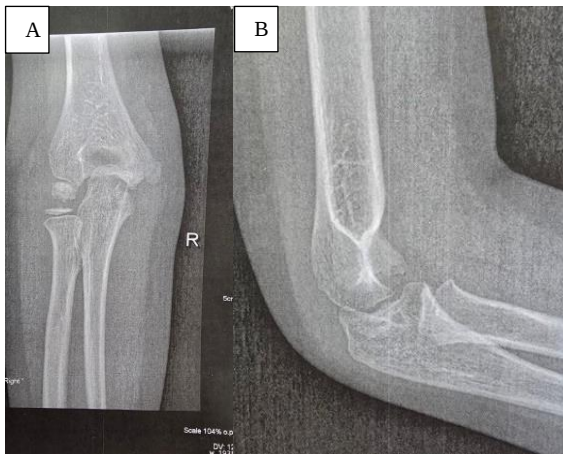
A) Anteroposterior (AP) elbow radiograph at 24 months demonstrating a central trochlear concavity (“fishtail” deformity) with preserved coronal alignment; B) Lateral elbow radiograph at 24 months showing subtle trochlear contour irregularity with maintained ulnohumeral congruity
